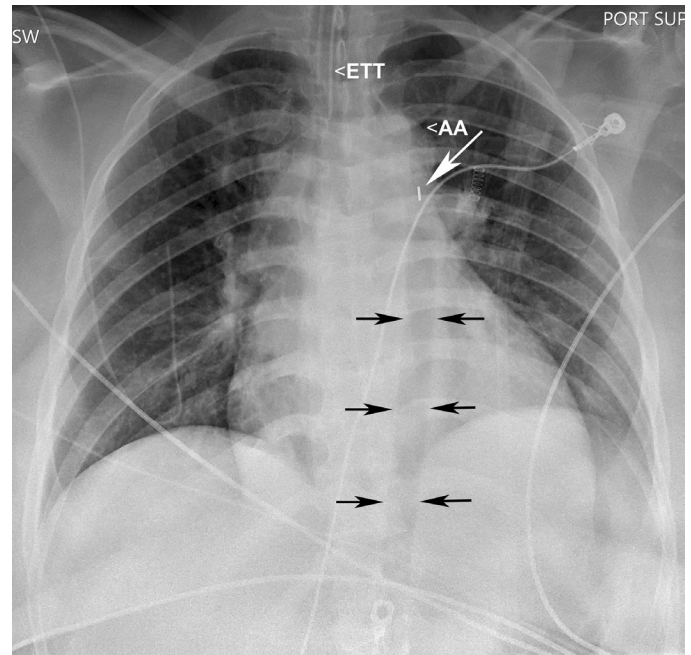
■ Anteroposterior (AP) supine chest x-ray. Intraaortic balloon pump (IABP) is in proper position with a proximal cylindrical marker (white arrow) just below the aortic arch (AA). When the x-ray was taken, the balloon happened to be inflated and can be easily recognized (outlined by smaller black arrows). Endotracheal tube (ETT) is also present and in the proper position.
